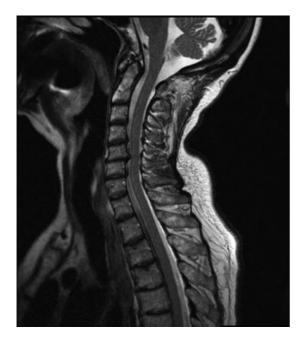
Preoperative T2-weighted sagittal magnetic resonance imaging clearly demonstrating a large disk-osteophyte complex at the C5–C6 level.
